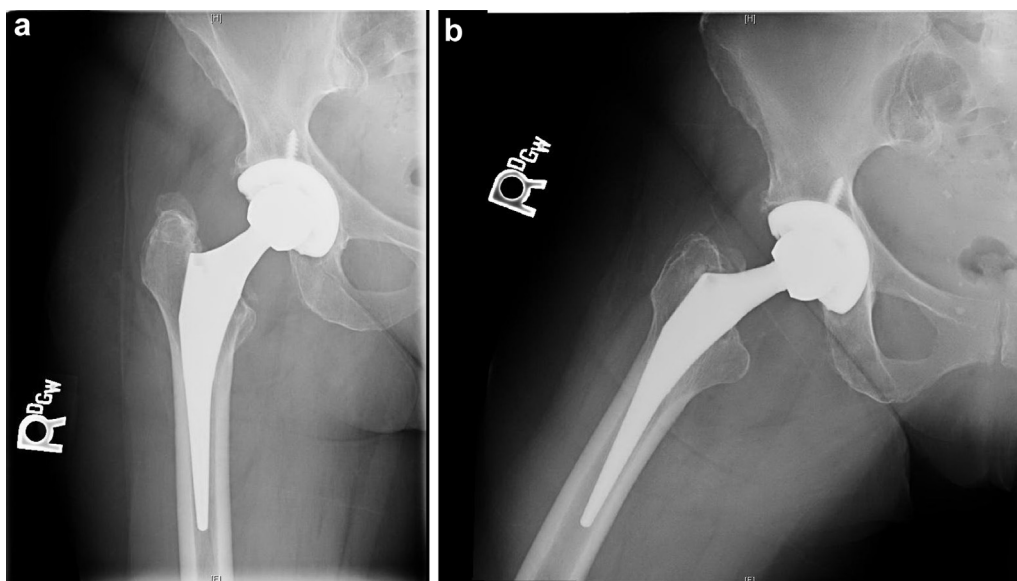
AP (a) and lateral (b) radiographs of the right hip upon presentation approximately 5 years after the initial right THA show no sign of complication.
